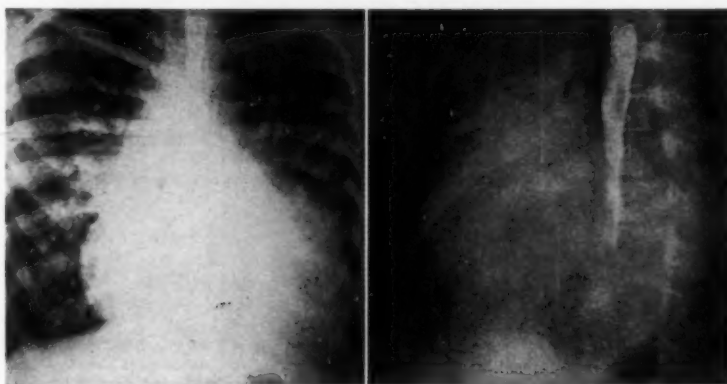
Preoperative roentgenograms of ten year old girl (No. 4 on Table 3) with rupture of right aortic sinus aneurysm into the right ventricle. There is marked cardiomegaly. Advanced left ventricular enlargement is demonstrated in the oblique view.
